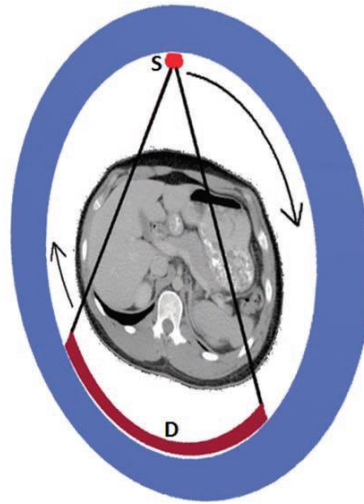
CT scanner, x-ray tube and detector array arrangement.
